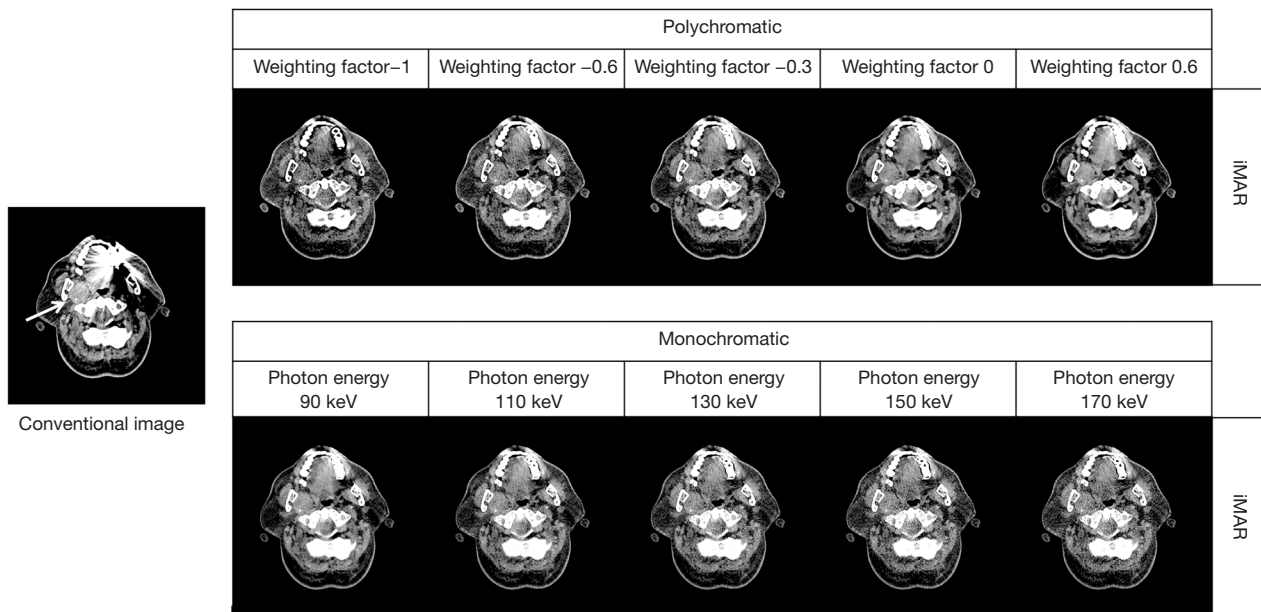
DE head and neck CT image of an 80-year-old man with a mass in the right contralateral muscle (arrow). Metal artifacts from the dental implant obstructed details such as the mass boundary and density. Conventional image means DECT polychromatic image with 0.6 composition ratio and without iMAR, which is equivalent to a 120 kV image. Compared with conventional images, DECT images combined with iMAR can significantly reduce the metal artifacts of the image and clearly delineate the tumor boundary. iMAR, iterative metal artifact reduction algorithm; DE, dual energy; CT, computed tomography; DECT, dual-energy computed tomography.
